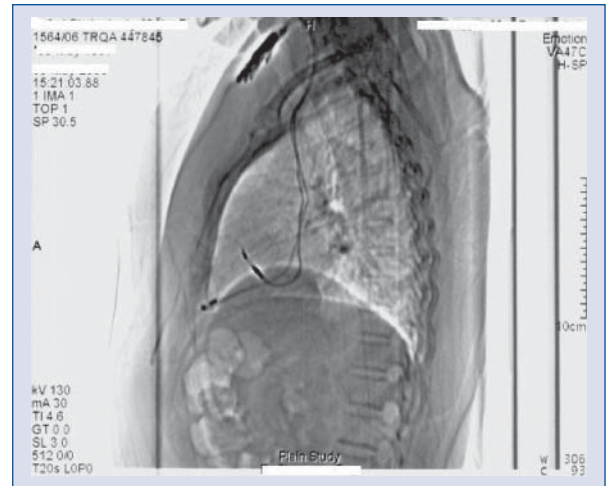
Computed tomography scan showing perforated ventricular lead — lateral view.
